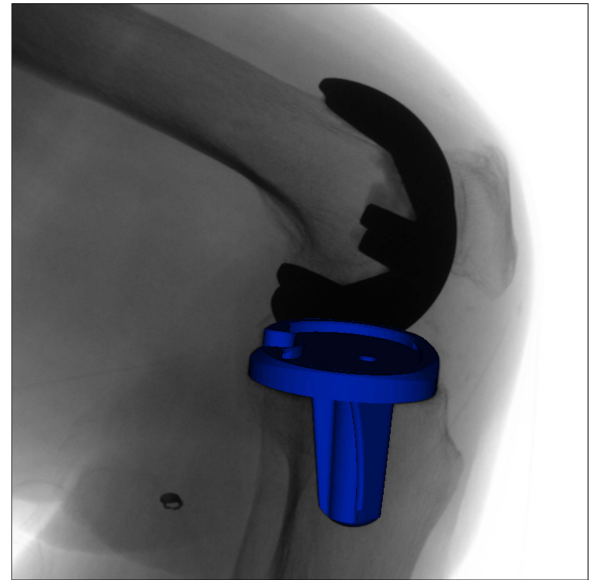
Radiographic image of the moving knee with the correct projection of a tibial implant superimposed.
